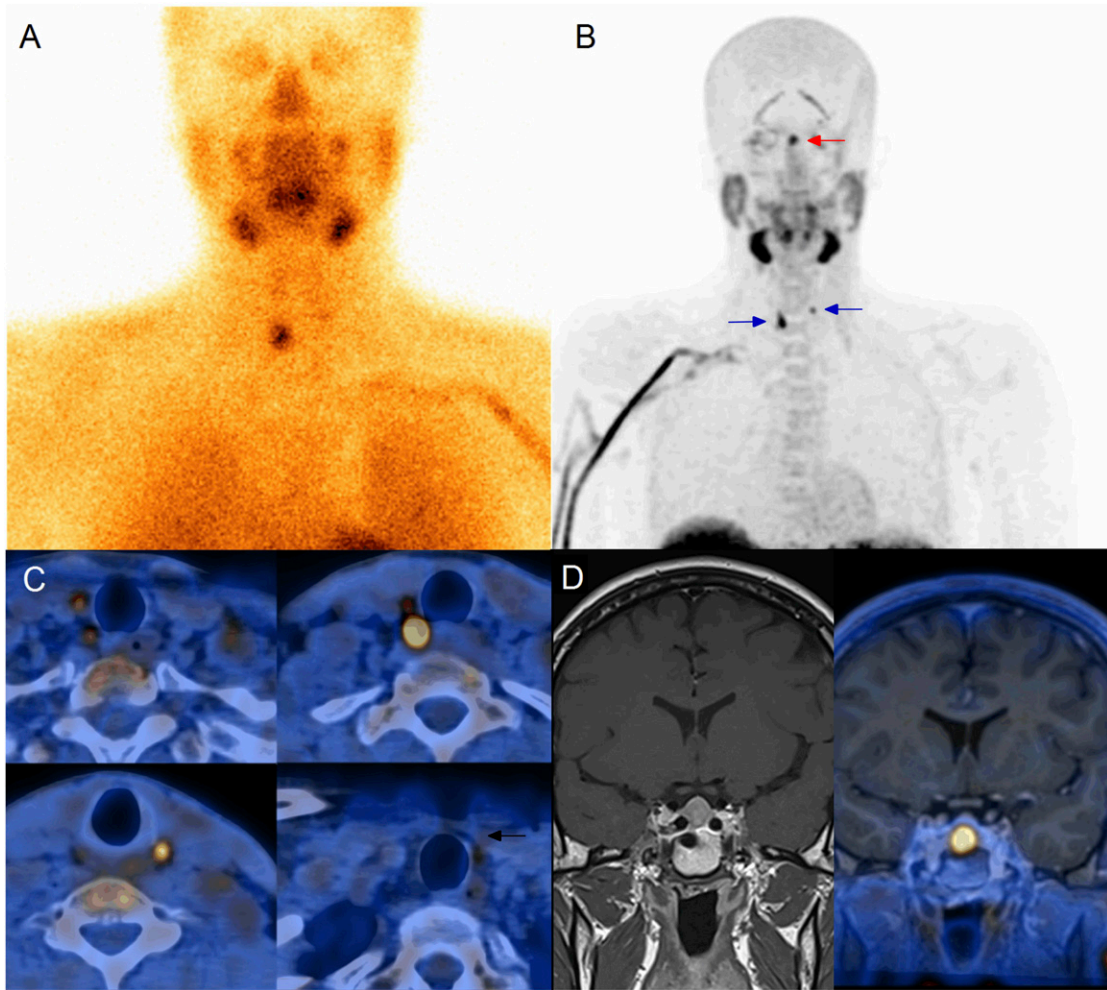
Macroprolactinoma visualized by ^{18}F -Fluorocholine PET/CT. (A) Parathyroid scintigraphy with metoxyisobutylisonitil labeled with technetium-99m (MIBI) with focus of uptake in the right upper parathyroid gland. (B) Maximum intensity projection of FCH-PET visualized two parathyroid glands (blue arrows) and also a macroadenoma (red arrow). (C) FCH-PET/CT fused view showed an increase of uptake in all four parathyroid glands. Arrow shows inferior left parathyroid. (D) On the left, gadolinium T1-weighted pituitary MRI showed a macroadenoma of $11 \times 10.5 \times 13$ mm and on the right FCH-PET/MRI fused view showed the increased focus of uptake in macroprolactinoma.
